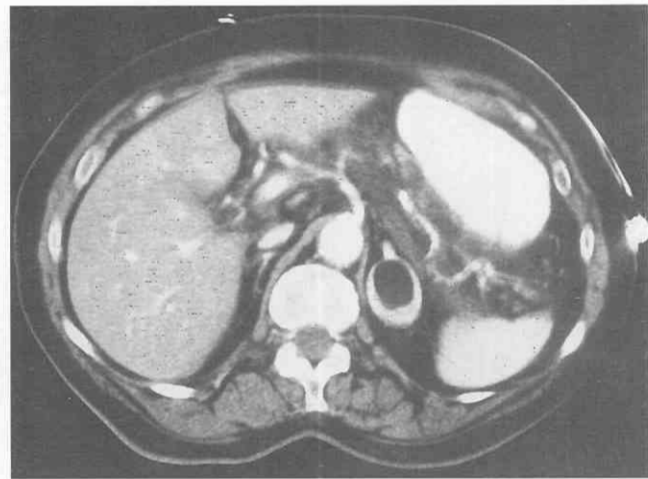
Adrenal myelolipoma. Contrast-enhanced CT scan of the abdomen demonstrates a 3.5-cm left adrenal mass containing a large amount of fat. This mass is characteristic of an adrenal myelolipoma.
